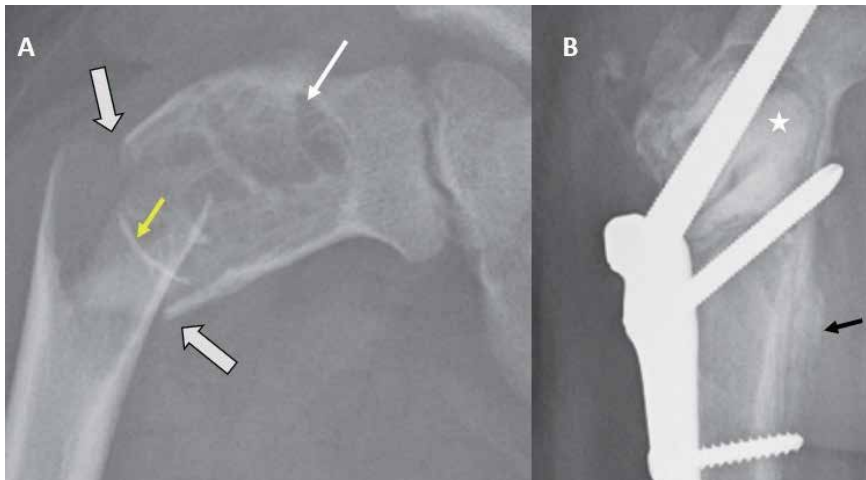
Simple Bone Cyst: Frontal radiograph of the right femur (A) demonstrates a pathological fracture (thick arrows) through a circumscribed expansile lytic proximal meta-diaphyseal lesion (white arrow). It represents a simple bone cyst with the characteristic fallen-fragment sign (yellow arrow). A follow-up post-treatment frontal radiograph of the right femur (B) shows graft material (white asterisk) cementing the bone cyst and a transfixed healing fracture with good periosteal reaction (black arrow).
